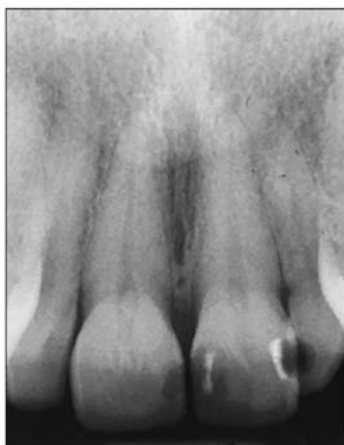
Periapical radiograph of a peg lateral incisors, #7 and #10.
